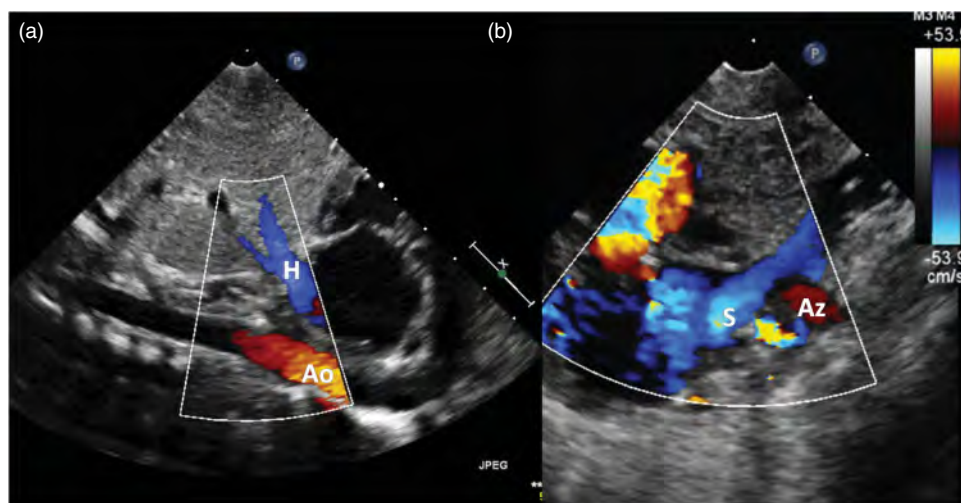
Two-dimensional echocardiography of interrupted IVC with azygos continuation in a patient with heterotaxy. (a) The hepatic vein (H) entering the right atrium directly. (b) The azygos vein (Az) entering the right SVC.
